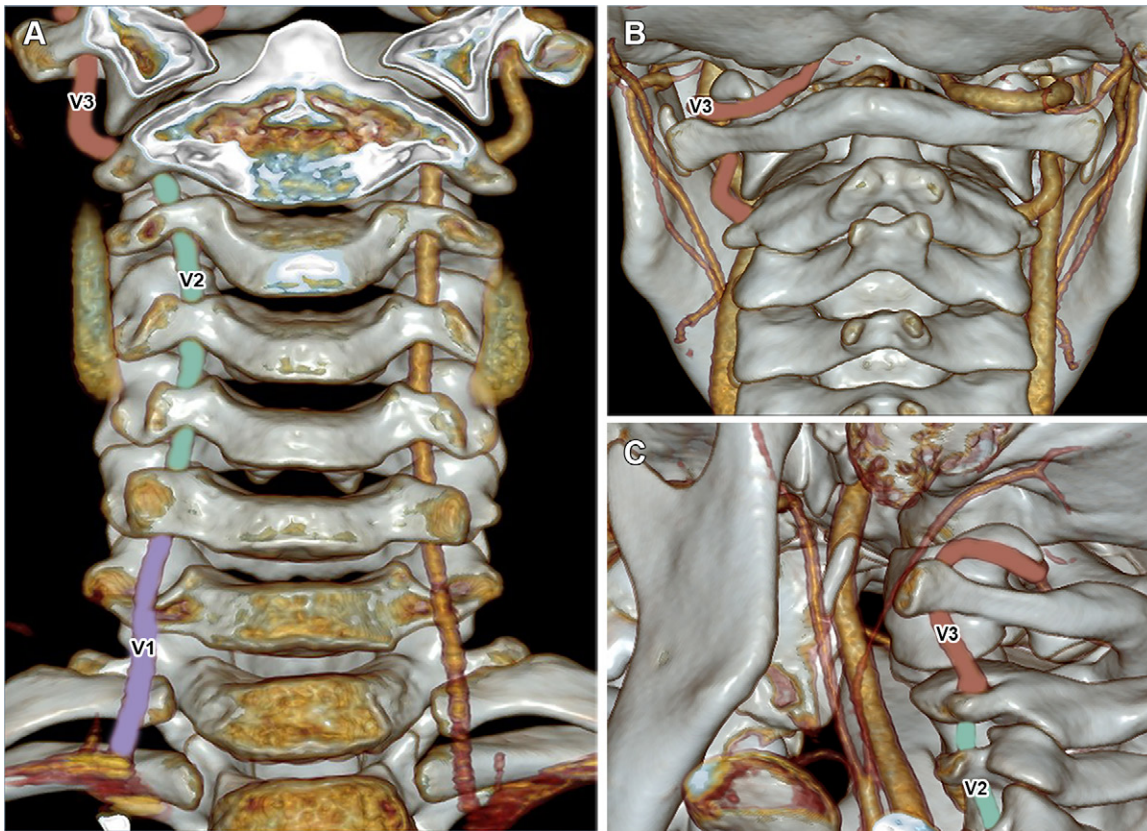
Volume-rendered CT angiograms show the most common configuration of normal vertebral artery anatomy. Coronal image with anterior view (A), coronal image with posterior view (B), and sagittal oblique view from the patient's left side (C) are shown. The V1, or preforaminal segment (purple), extends from the origin to the transverse foramen of C6. The V2, or foraminal segment (teal), extends from the transverse foramen of C6 to the transverse foramen of C2. The V3, or atlantic, extradural, or extraspinal segment (red), starts from C2, where the artery loops and turns laterally to ascend into the transverse foramen and continues through the C1 transverse foramen to enter the dura. The V4, or intradural segment, is not shown.
